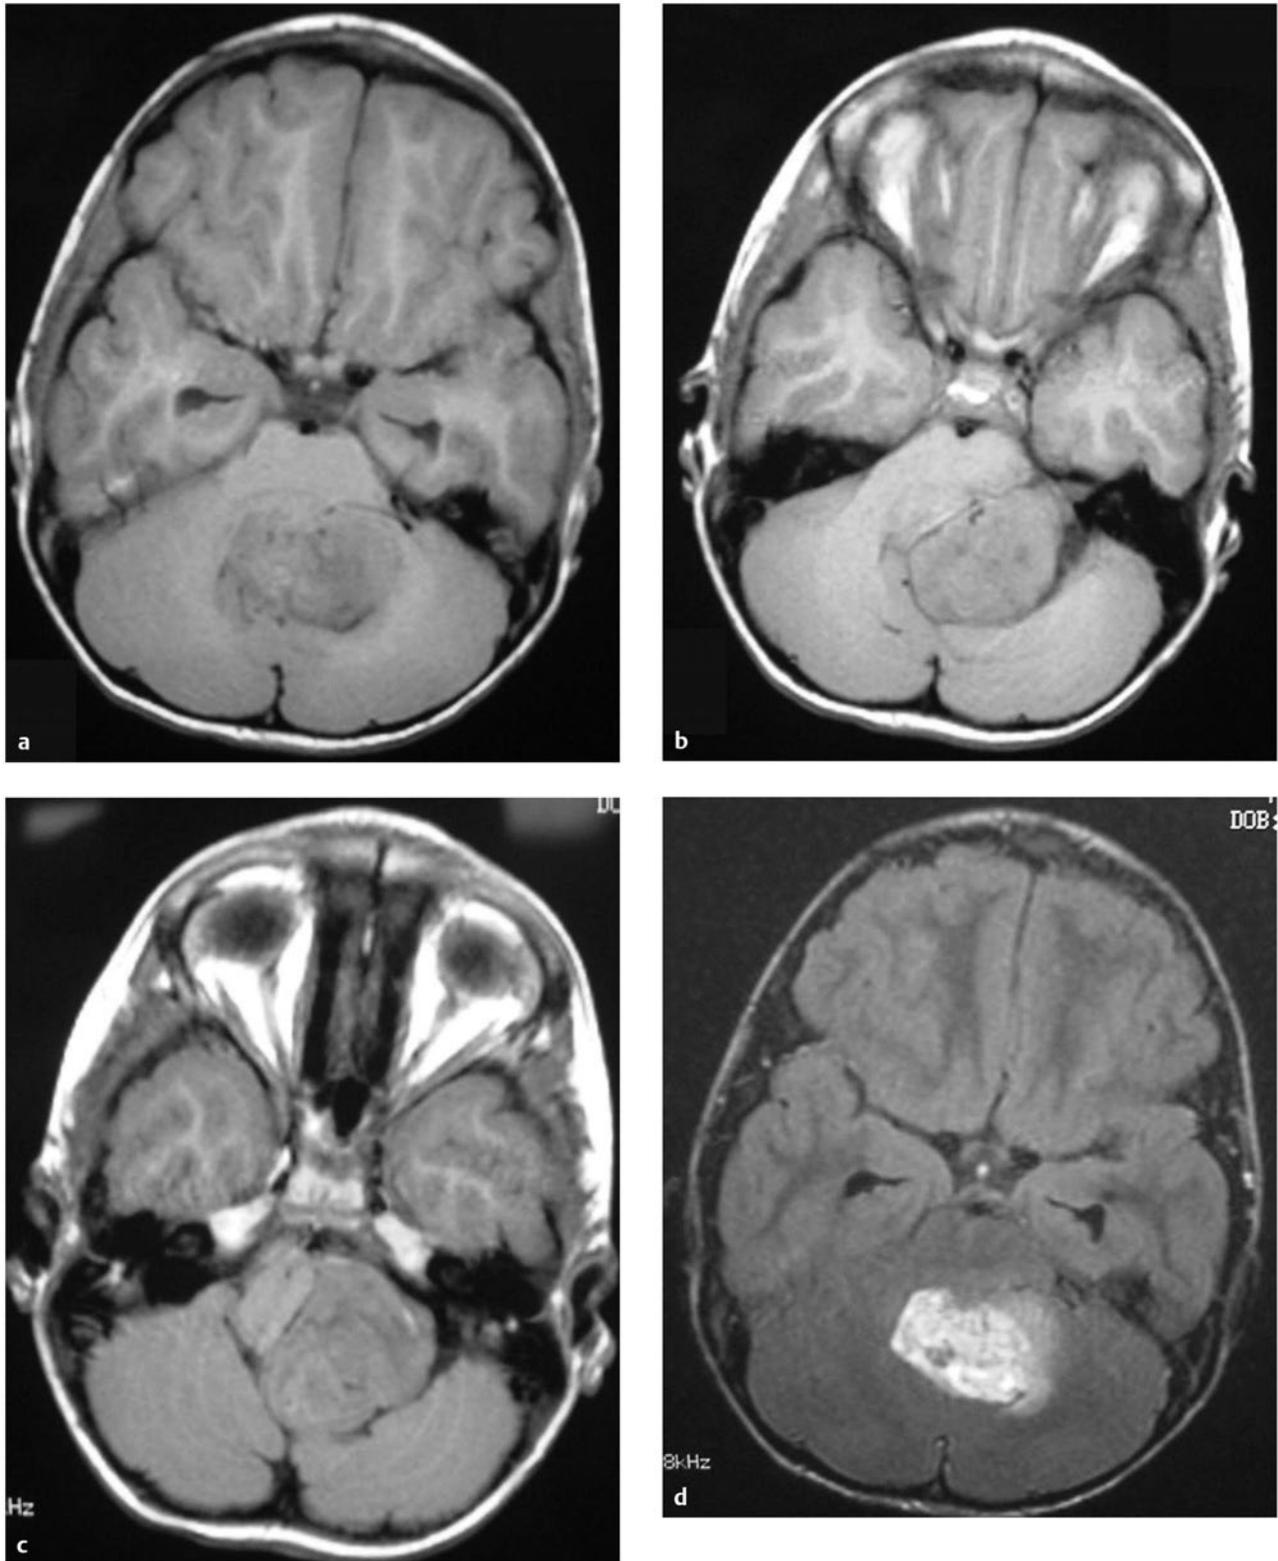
A 7-year-old with 4 weeks of headache and vomiting. (a) An unenhanced T1-weighted magnetic resonance (MR) image shows a low-signal mass lesion within the fourth ventricle with extension into the cerebellopontine angle (CPA). (b) The extra-axial component of this tumor has severely compressed the brainstem and displaced it to the right. The anatomy of the displaced, rotated brainstem can be very confusing at the time of surgery. (c) Axial T1-weighted MR image with gadolinium shows enhancement of the lesion in the fourth ventricle. (d) The enhancing mass extends out of the foramen of Luschka. (*continued*)
